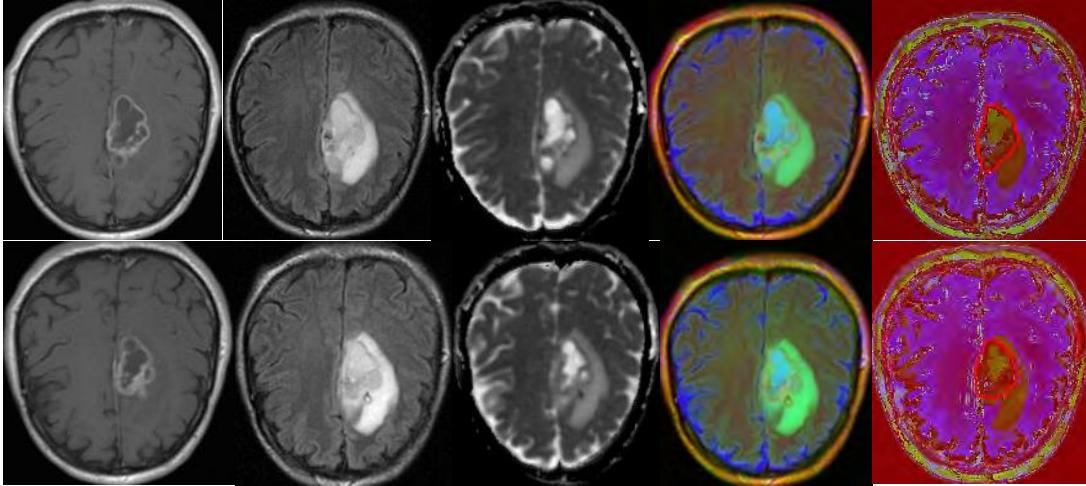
Original T1W, T2-FLAIR, and ADC images (column 1 to 3), combined color image (column 4), and generated signature map (column 5). Red Lines denote the expert tumor delineations.
